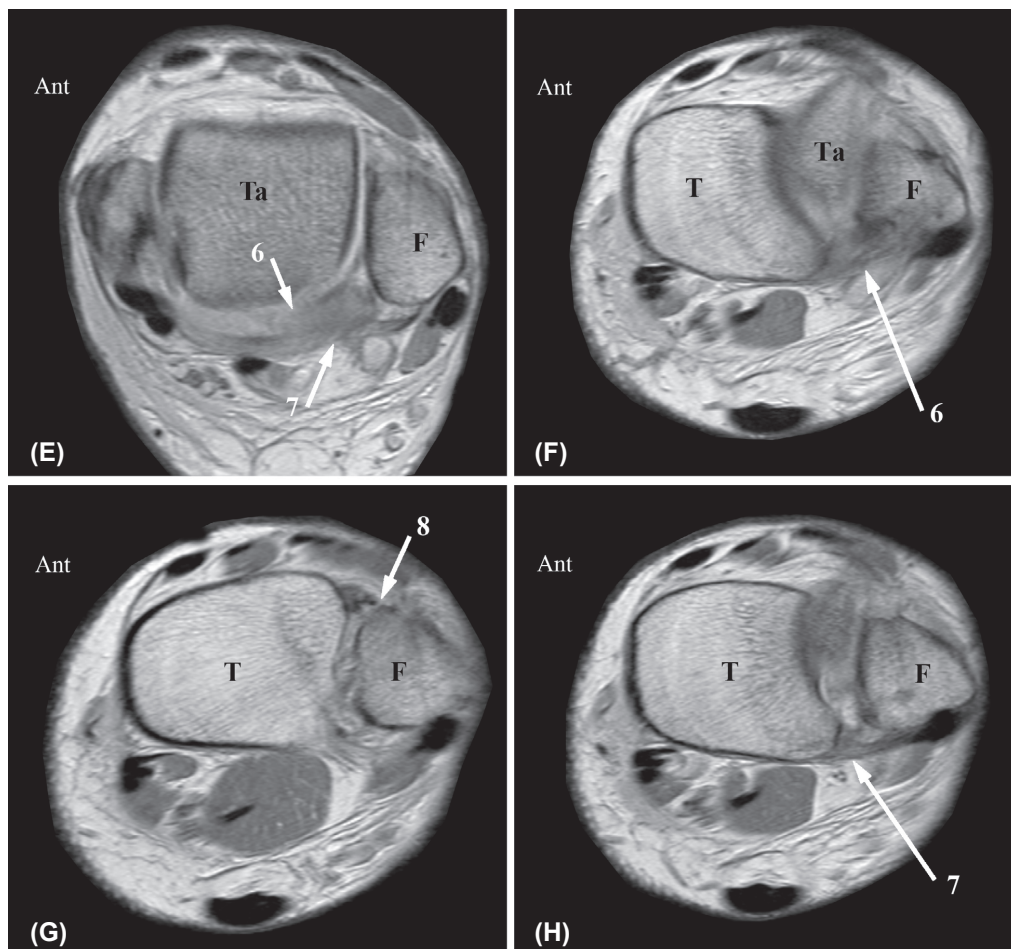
AP (A) and lateral (B) radiograph. Short distal fibula fracture (1) extending from just below till just above the level of the tibiotalar joint line. Measurements are normal. This fracture is classified as: Weber type B, AO-Müller type B1.1 and Lauge-Hansen SE2. Coronal (C, D), axial (E) and 45° oblique (F, G, H) proton-density-weighted MR images. The coronal MRI (C, D) shows the fibula fracture (1), a postero-lateral osteochondral lesion of the talar dome (2), a normal interosseous ligament (3), a thickened superficial (4) and a normal deep (5) deltoid ligament. On the axial (E) and oblique MR image (F) the transverse ligament (6) is ruptured. The PTIFL (7) appears to be ruptured in the axial plane (E) but is still continuous, although thickened, in the 45° oblique plane (B). The ATIFL (8) is ruptured (G). With the MRI findings this would change the fracture into a AO-Müller type B1.2 but it would still be Lauge-Hansen SE2. Ant, anterior; Ta, talus; T, tibia; F, fibula.
